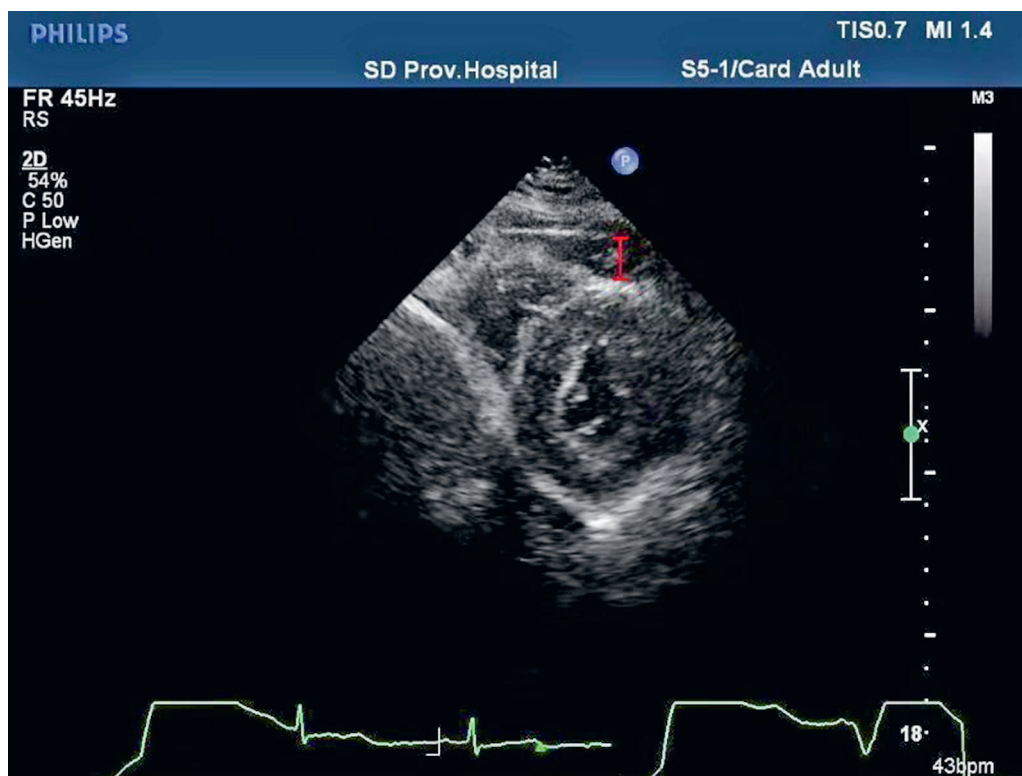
Measurement of EAT-ivg on the anterior interventricular groove in the parasternal short-axis view. The red line shows the measurement distance
